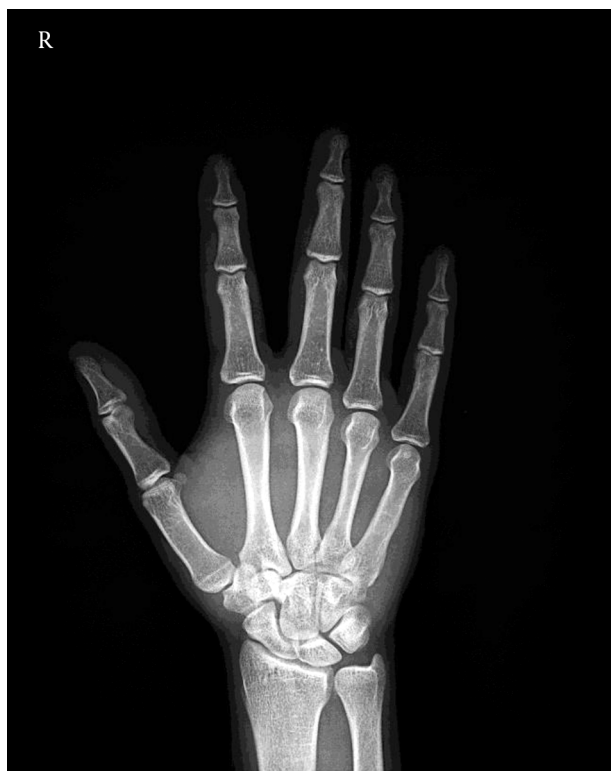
Anterior-Posterior Radiograph of Wrist
